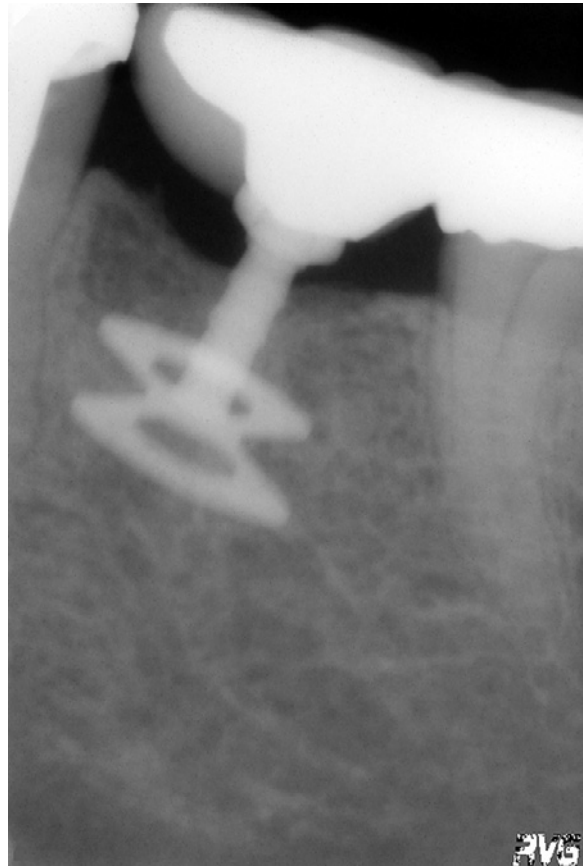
If BOI implants are placed between teeth, similar mineralization patterns emerge. The more strongly mineralized cortical bone of the alveolar socket can be seen around the teeth. Crestally of the disk, the bone is mechanically inactive and therefore rather less strongly mineralized. More pronounced mineralization around the threaded pin is only seen with earlier disk implants (as in this radiograph 5 years postoperatively) that transmit masticatory forces both at the threaded pin and at the disk. This type of BOI implant, due to higher material strength and stronger design, allows less interbony oscillation than implants made from pure titanium
